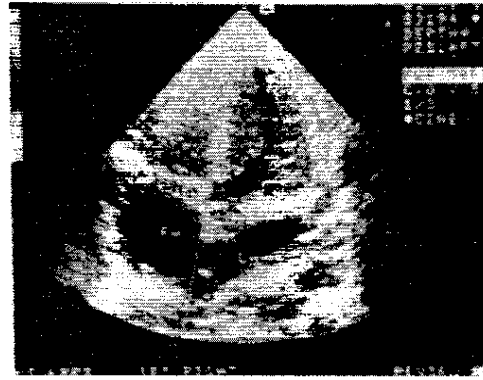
Colour flow Doppler showing aortic regurgite in a patient with mucopolysaccharidosis type I
